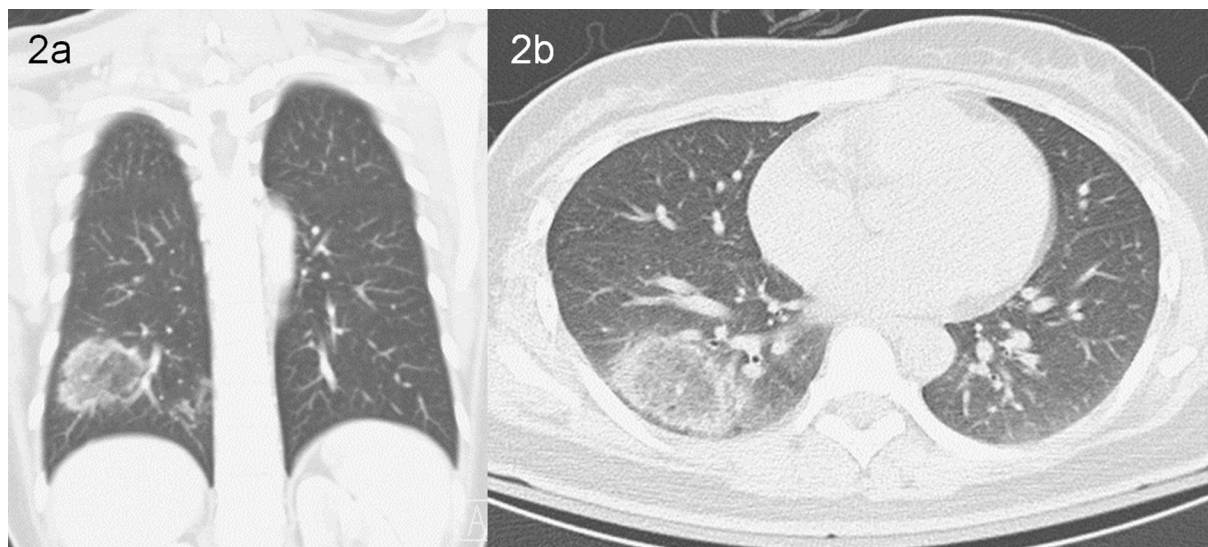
Chest computed tomography scan of the lung window revealing a 5.6×3.2 cm ring-shaped consolidation with central ground-glass opacity at the right lower lobe, which is a typical reversed halo sign. (a) Coronal section view. (b) Axial section view.
